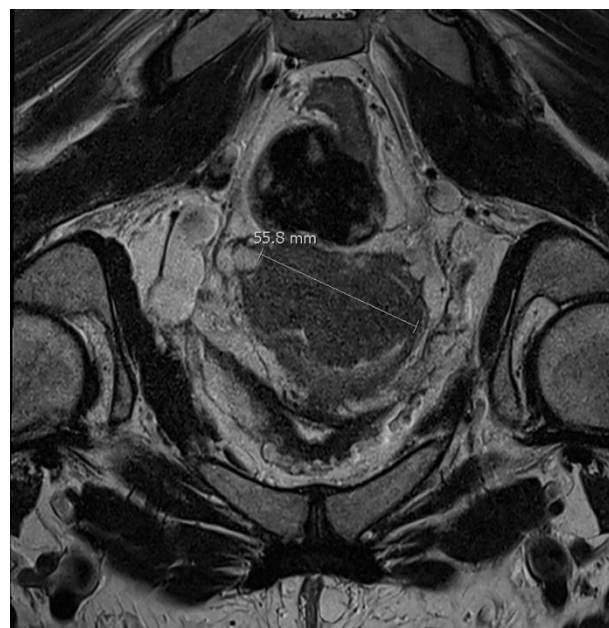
Cervical mass (coronal view, MRI).
